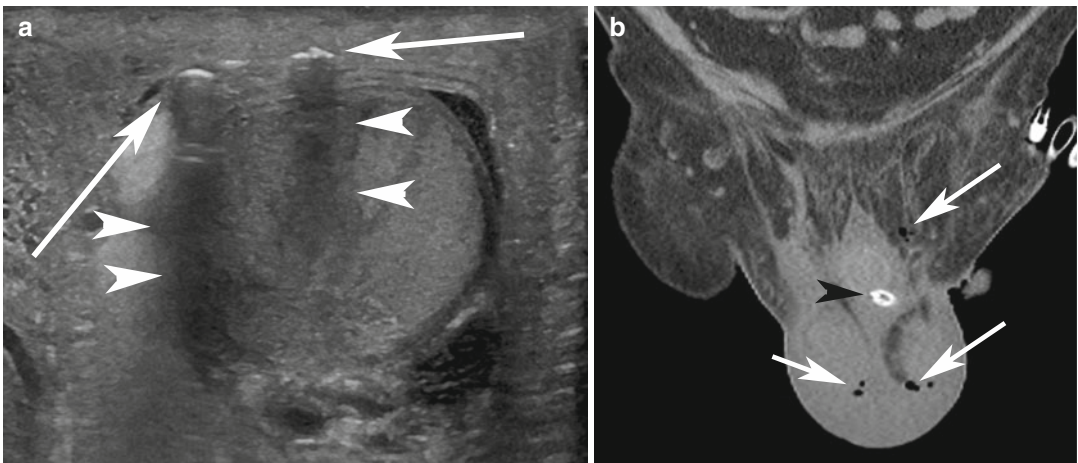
Seventy-eight-year-old man with diabetes mellitus and diagnosis of Fournier gangrene. (a) Ultrasound image shows foci of air (arrows) in the subcutaneous tissues, identified as echogenic areas with shadowing (arrowheads).
